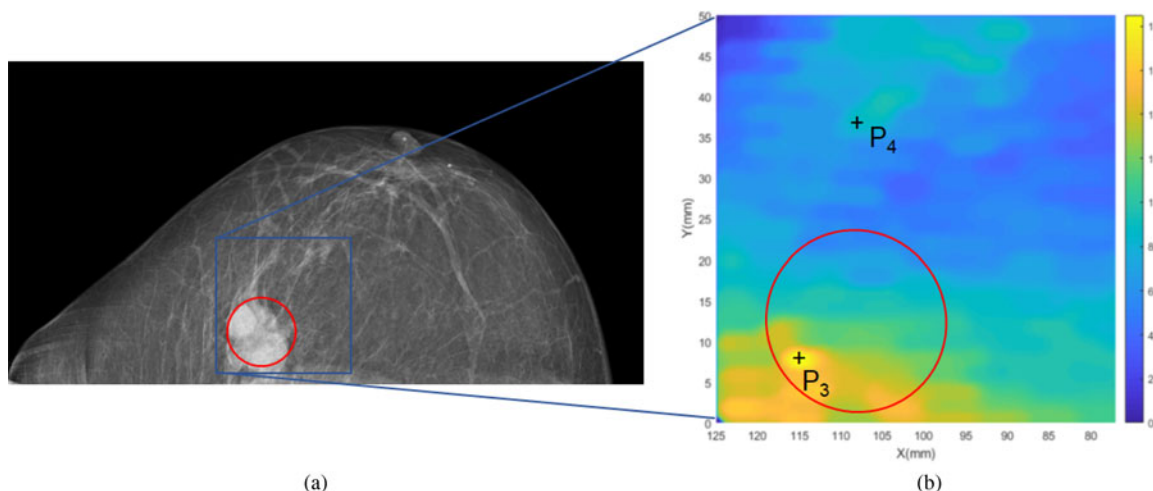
Comparison between X-ray image and microwave image for patient B. The microwave image is formed by calculating the signal's attenuation. Locations with higher attenuation could be interpreted as cancerous tissue. The final thickness of the compressed breast is 43 mm during microwave examination and is 37 mm during X-ray examination.
